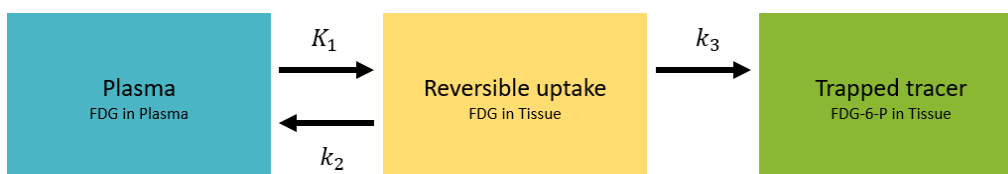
Two-tissue compartmental model for FDG.
